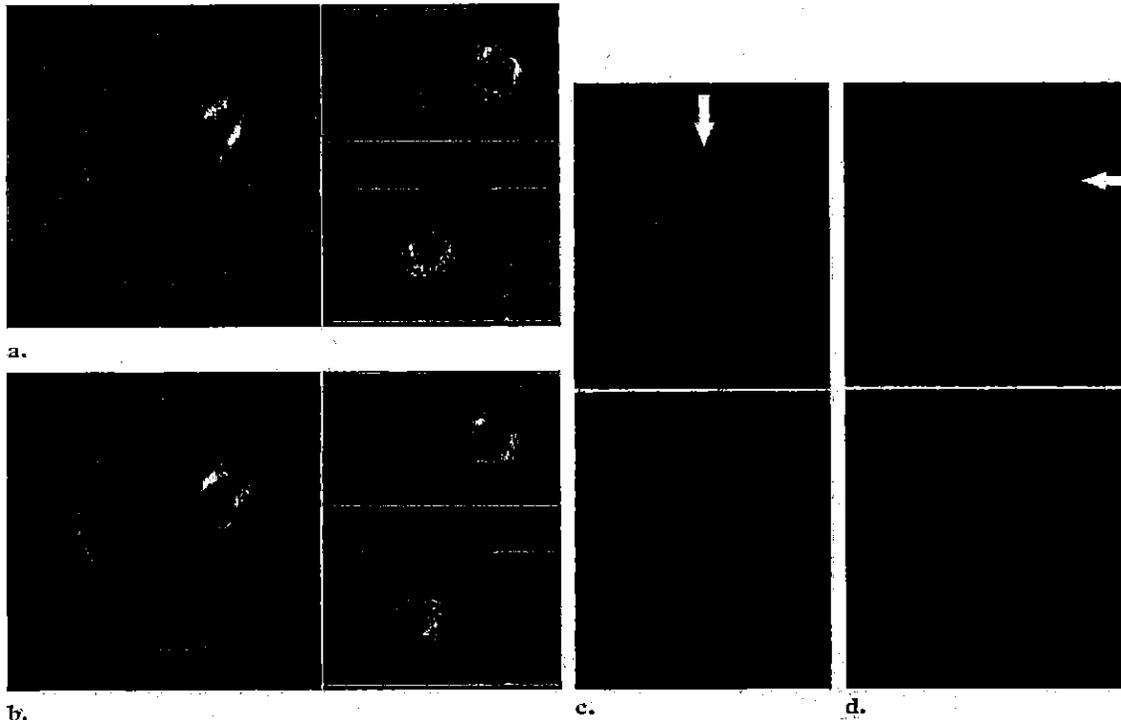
Attenuation correction defect caused by patient movement between studies and misregistration. (a) Fused SPECT/CT images show slight misregistration of the imaging data, with the SPECT images moved laterally and posteriorly. (b) Fused SPECT/CT images show correction of the misregistration. (c, d) Representative short-axis (c) and vertical long-axis (d) SPECT/CT images of the heart show misregistration of the imaging data (top) and correction of the misregistration (bottom). The apparent defect in the distal anterior wall (arrow) is an artifact from an incorrect attenuation correction map.
